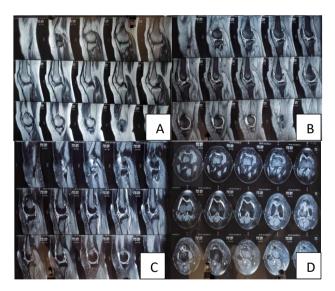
(A-D): As per modified outerbridge classification based on MRI Grade IV osteoarthritis of knee joint in a patient.
